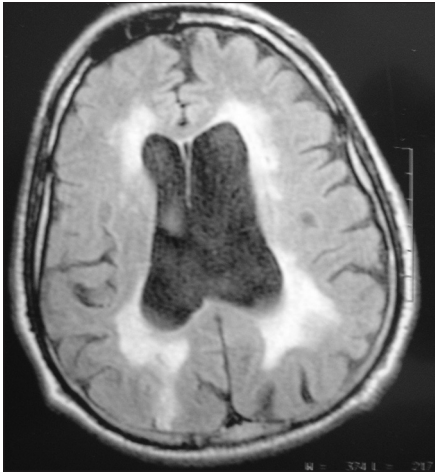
Hydrocephalus is seen on the preoperative axial MRI
